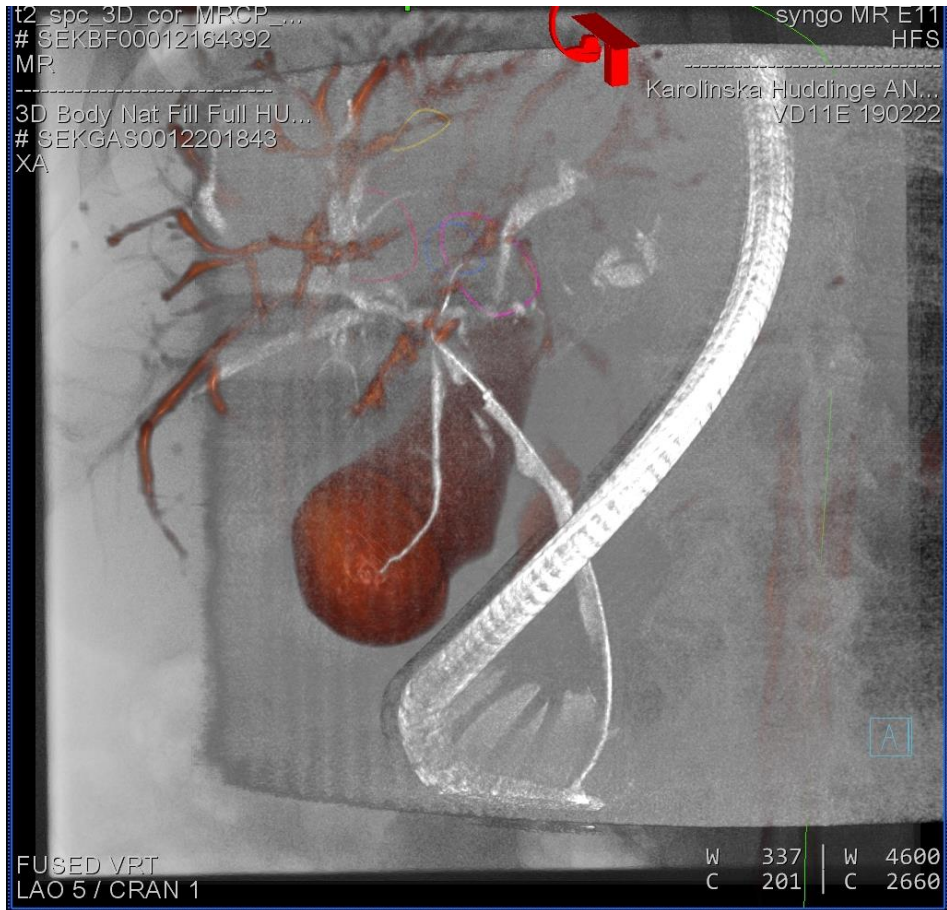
Advanced imaging during ERCP. The red image data are from a pre-interventional MRCP. The MRI dataset has been prepared for 2D/3D fusion with fusion lines (green) and circular markings for targeted ductal sampling. The grey image data come from an intraprocedural CBCT cholangiogram. Both modalities have been used to create a 3D/3D fusion and are blended over the fluoroscopy image. The pull of the duodenoscope on the bowel in the CBCT creates a slight offset and change in angles around the hilum.
